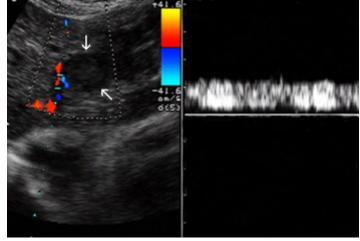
A 41-year-old man with a metastasis from gastric carcinoma: color Doppler sonography shows continuous peritumoral flow.
